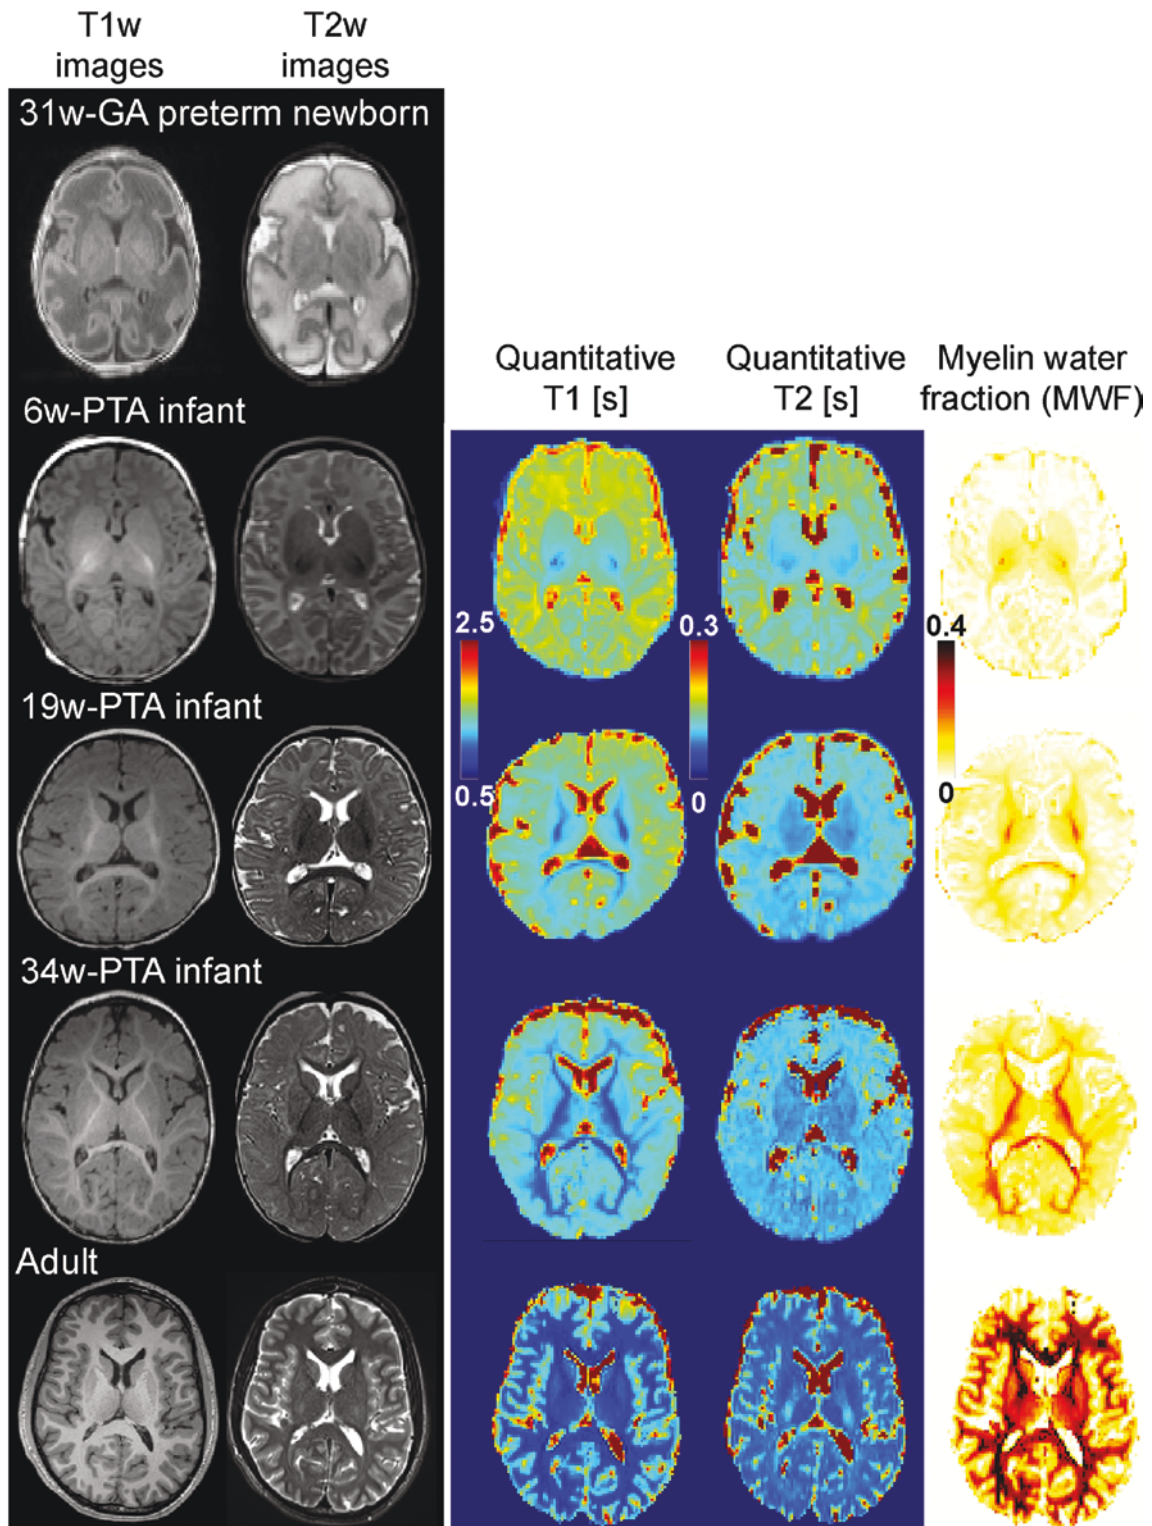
Anatomical images of the developing brain. T1-weighted and T2-weighted images are shown for subjects of 31 weeks of gestational age (GA), term-born infants at a post-term age (PTA) of 6, 19 and 34 weeks, and a young adult. Note the contrast inversion between grey and white matter during the first postnatal
